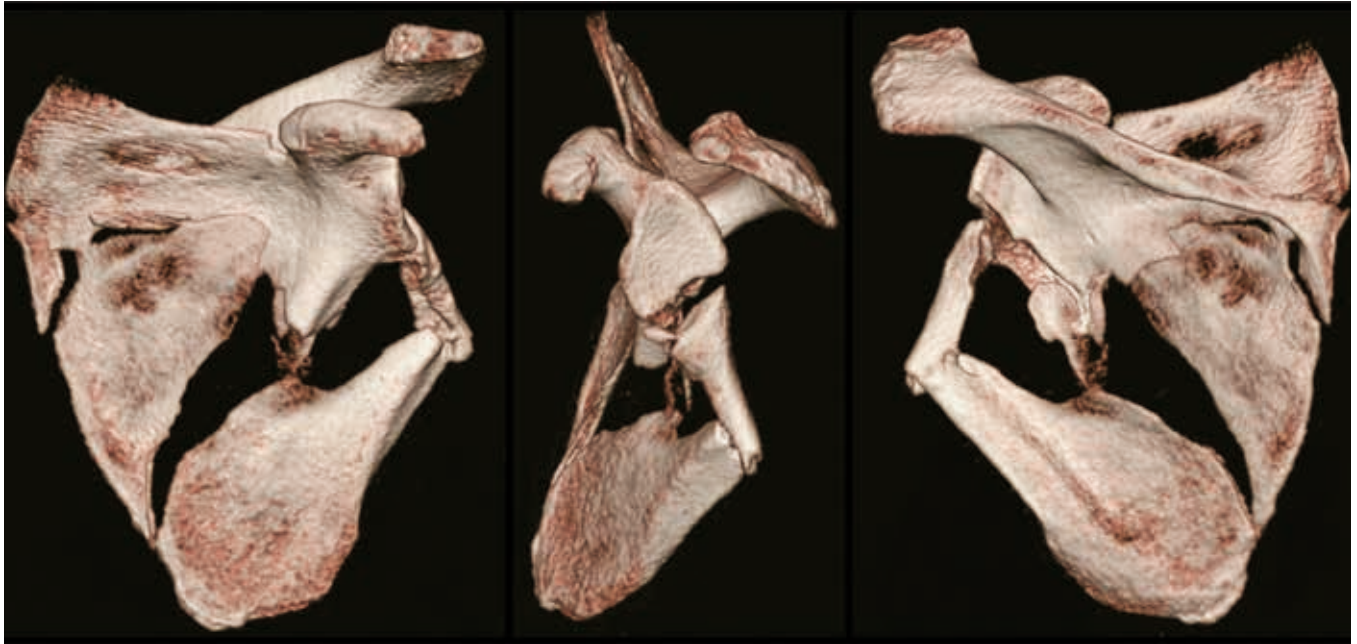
Fracture anatomy on 3D CT reconstructions.
